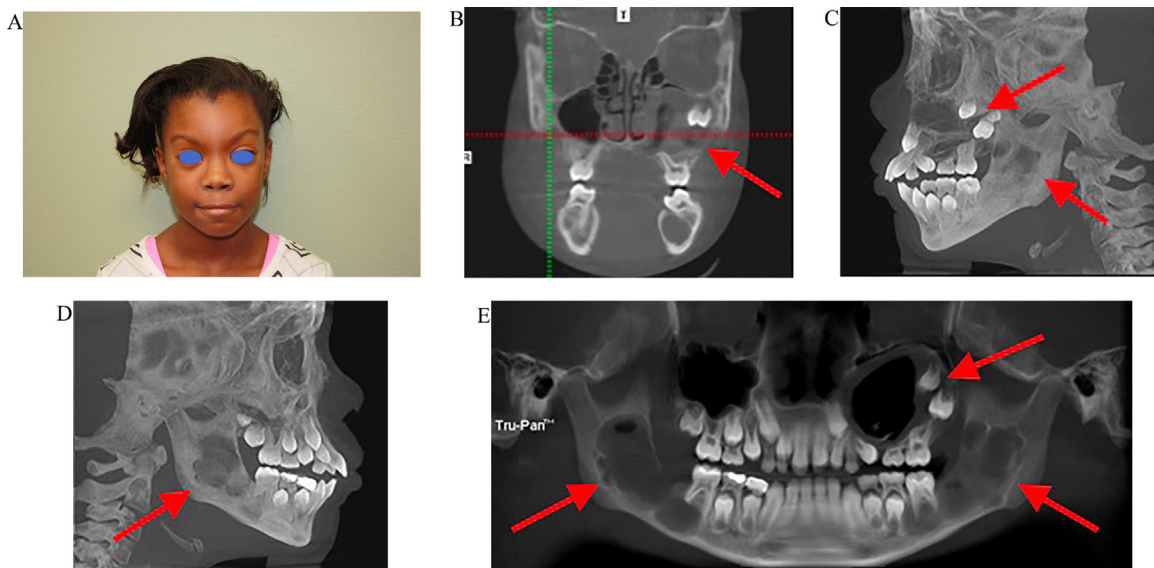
Clinical findings of a patient with Gorlin syndrome. (A) Frontal view demonstrates mild hypertelorism (A). CT images (B–D): Coronal section with left sinus obliteration (arrow) (B), radiolucent multicystic lesions in the right ramus (arrow) (C), and radiolucent multicystic lesions in the left ramus (arrow) (D). Panoramic radiography demonstrates bilateral mandibular ramus lesions and left sinus radiolucent and radiopaque lesions with an impacted tooth (arrow) (E).
